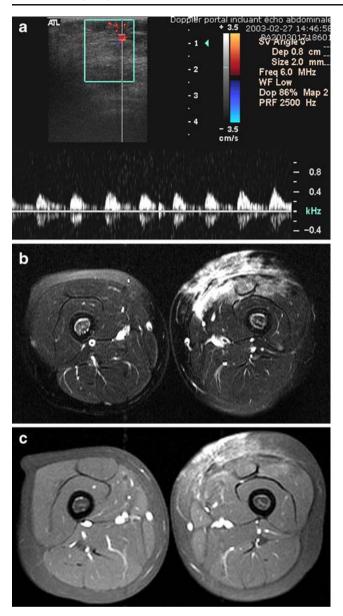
Three-year-old boy with red/purple-coloured soft-tissue mass in the anterior thigh. a Pulsed-wave colour Doppler US shows a few vessels with high resistance index. b Axial T2-W FS image shows an ill-defined hyperintense subcutaneous and muscular lesion. Subcutaneous stranding is clearly seen. c Axial contrast-enhanced FS T1-W scan shows heterogeneous diffuse enhancement. Biopsy confirmed the diagnosis of haemangioendothelioma
